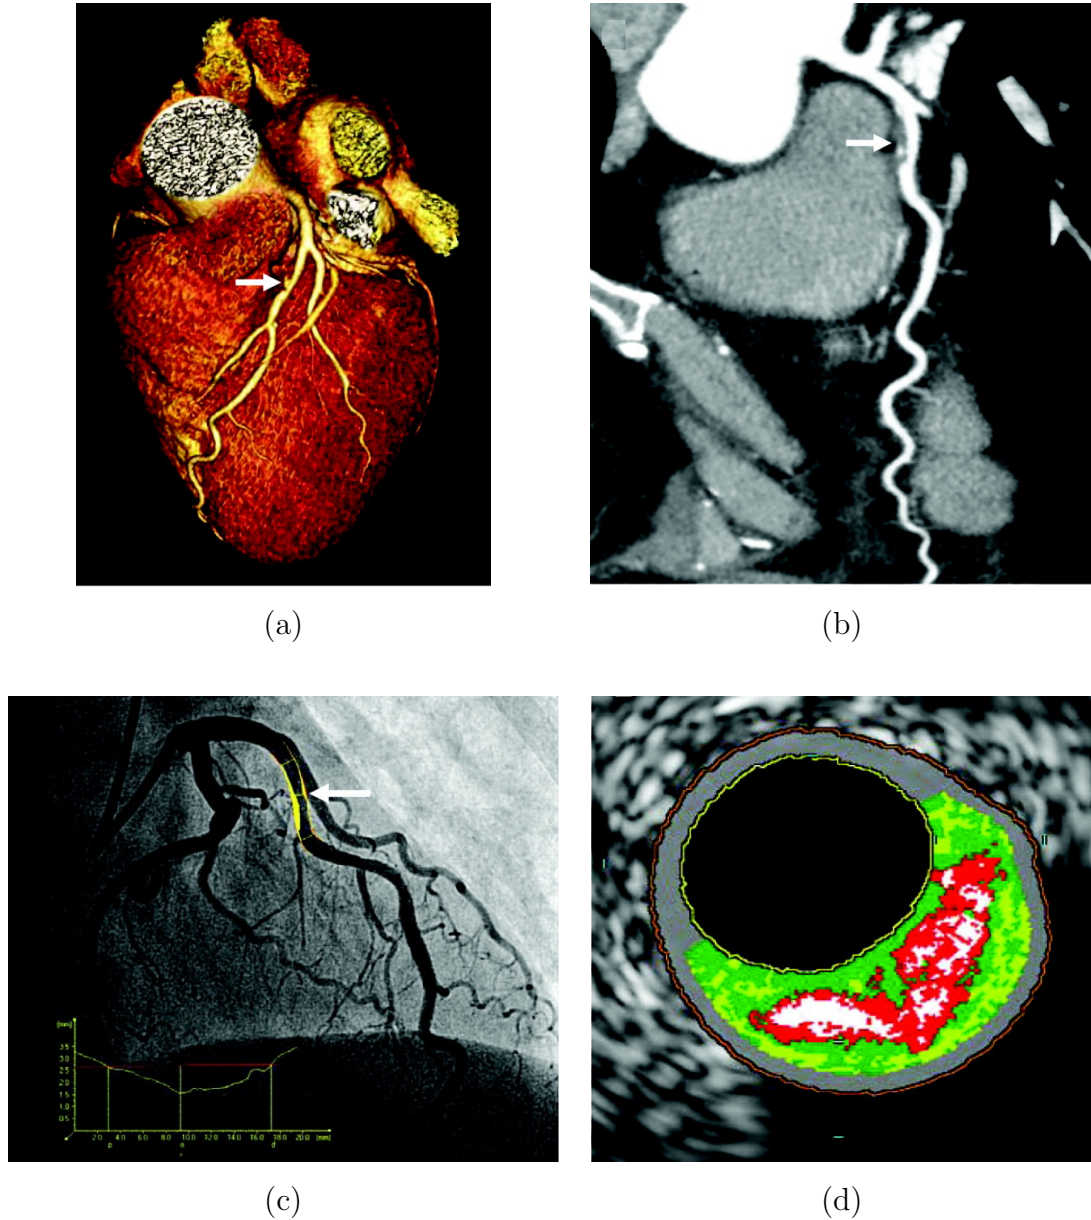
Combination of MSCT angiography, coronary angiography and IVUS. (a): Volume rendering of CT reconstruction, with arrow pointing to a lesion with intermediate luminal narrowing in the mid-section of the left anterior descending (LAD); (b): Curved multiplanar reconstruction of the LAD and its corresponding lesion; (c): Conventional coronary angiography, with the narrowing found on MSCT image confirmed; (d): A substantial amount of necrotic core (labelled in red) is shown in the corresponding IVUS image of the coronary segment [225].
